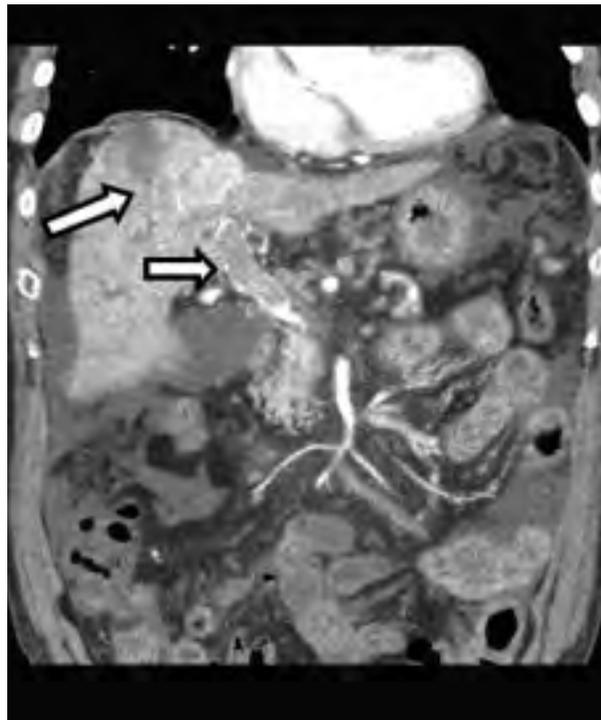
Contrast CT arterial coronal image of abdomen.
